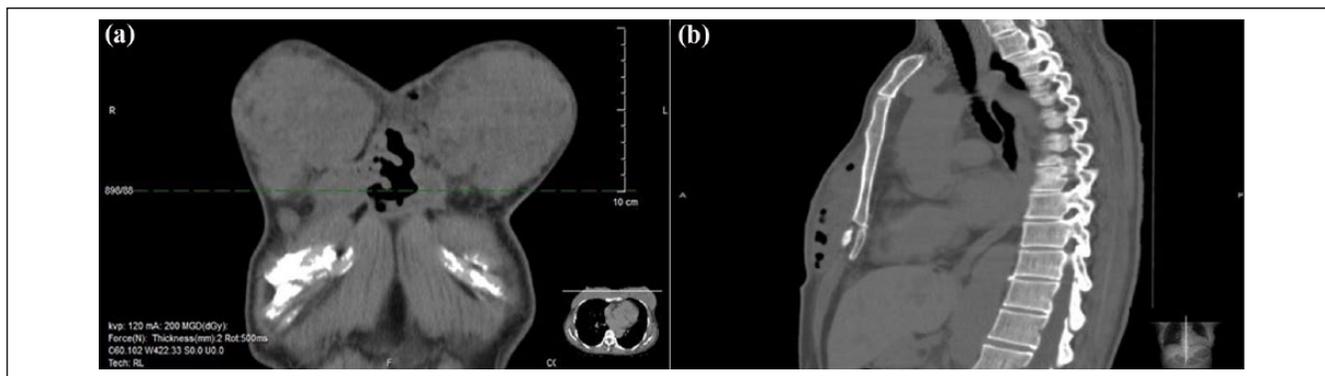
Transverse computed tomography images showing fluid collections, air bubbles, and foreign material. (a) is first photograph on the left (b) on the right.
